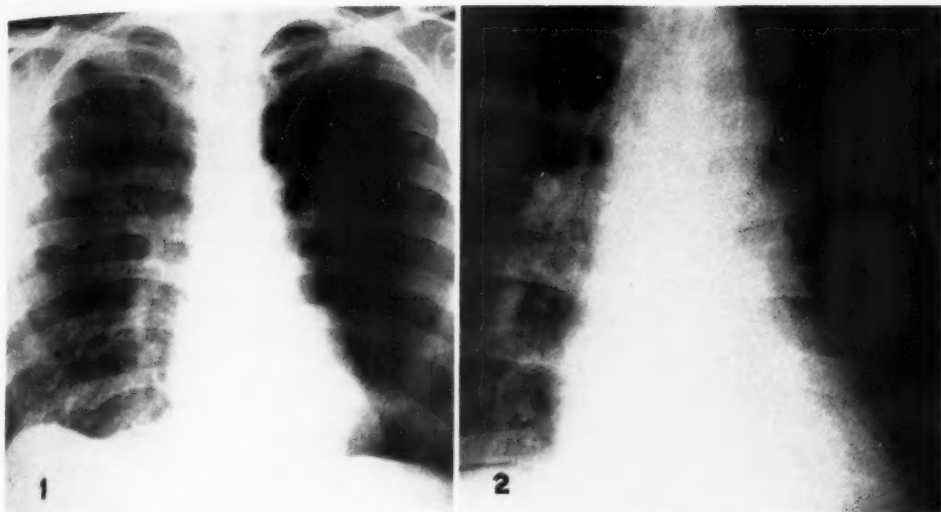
Inspiratory roentgenogram of thorax showing uniform marked increase in radiolucency of the left lung. The left hemithorax is slightly smaller than the right. The mediastinal structures are displaced minimally toward the left. This is best demonstrated during the fluoroscopic examination. There is marked decrease in lung markings on the left. The hilar shadow and pulmonary vessels are virtually absent as compared with the right side, where there is a luxuriant vascular supply. The left leaf of the diaphragm is flattened. The width of the rib interspaces on each side is the same.
